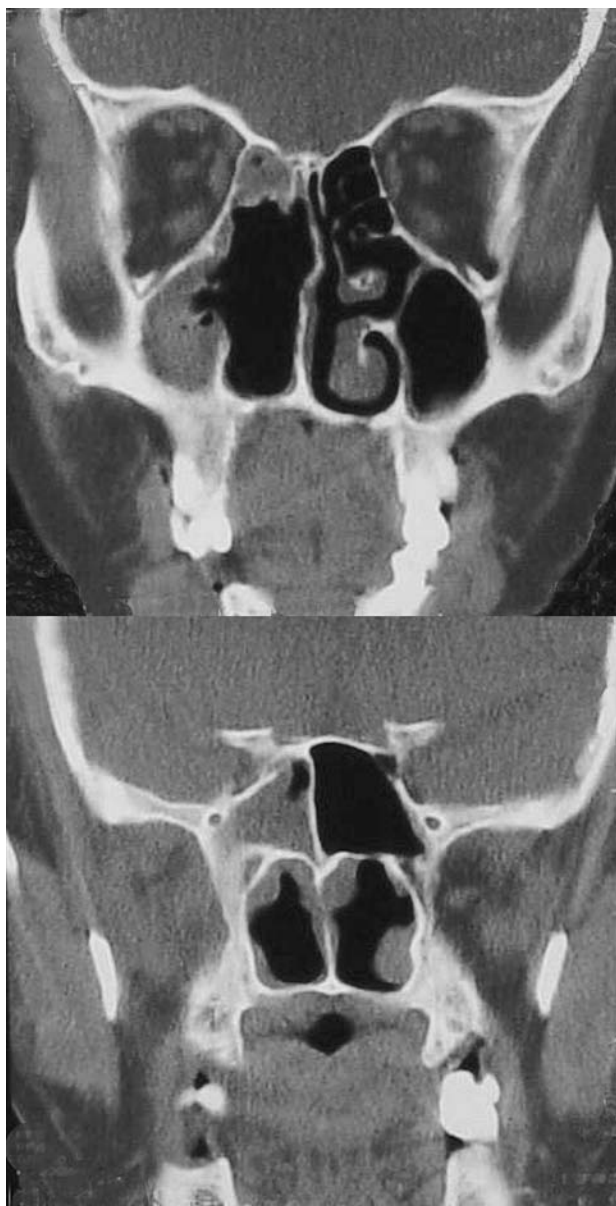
Coronal computed tomography scan with opacification of the left-sided sinuses (maxillary, ethmoidal, and sphenoidal).
